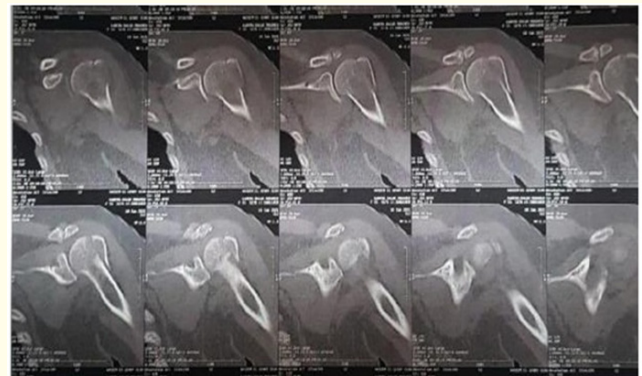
CT of shoulder: Coronal view.
